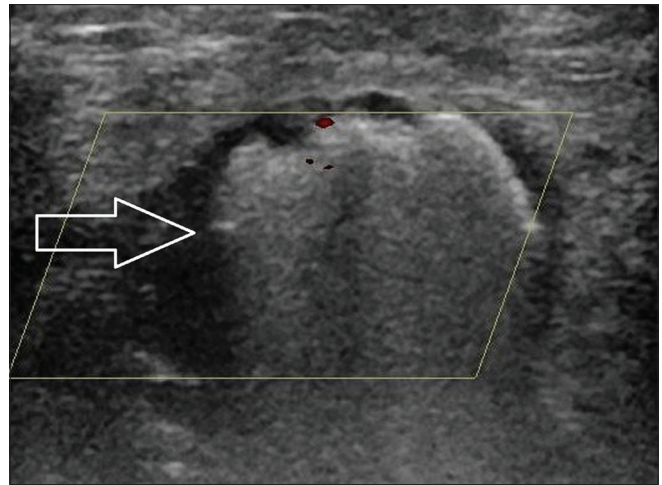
The 'snow-storm'effect (arrow) visualized on ultrasound during injection of the thrombin-collagen compound
